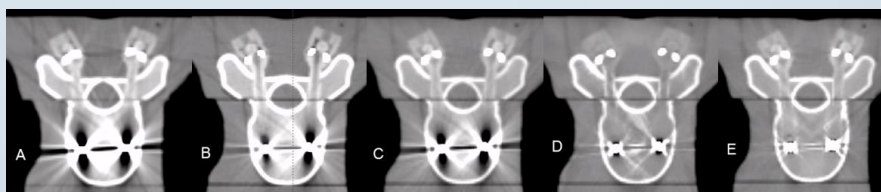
CFR-PEEK inserts reconstructed with iMAR and/or DECT. A) Raw CT B) Dental iMAR C) 160 keV DECT D) 160 keV DECT + neuro coil iMAR E) 160 keV DECT + dental iMAR
